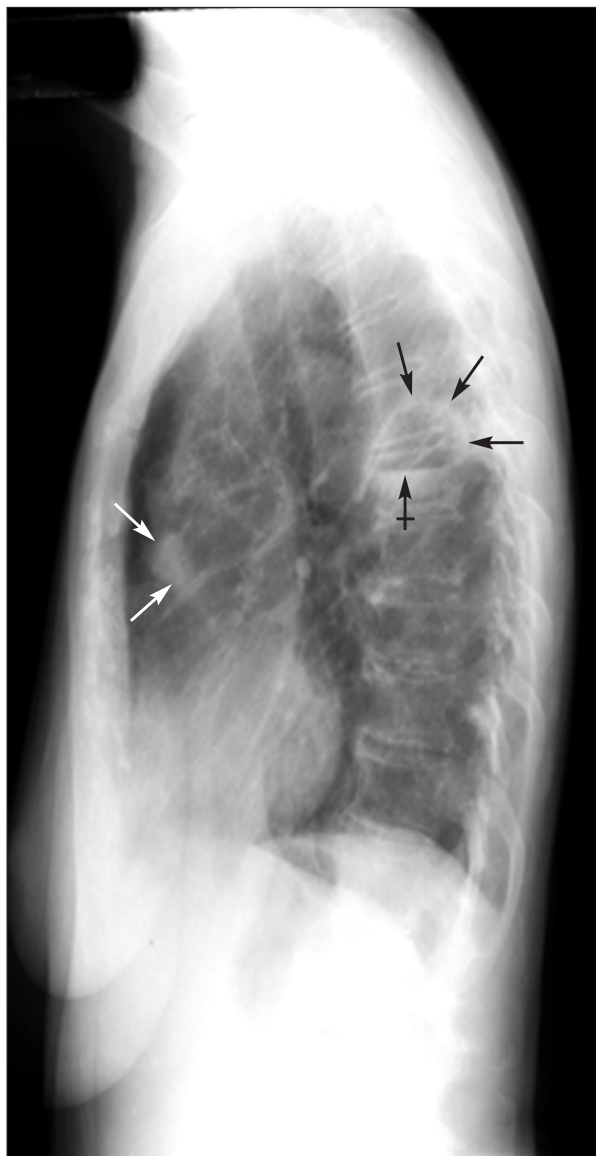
This lateral chest radiograph displays the posterior position of the cyst (three black arrows), which is typical of a lung abscess caused by aspirated material in a recumbent patient. The bar arrow points to the air-fluid level in the cyst. The two white arrows indicate the retrosternal granuloma.
